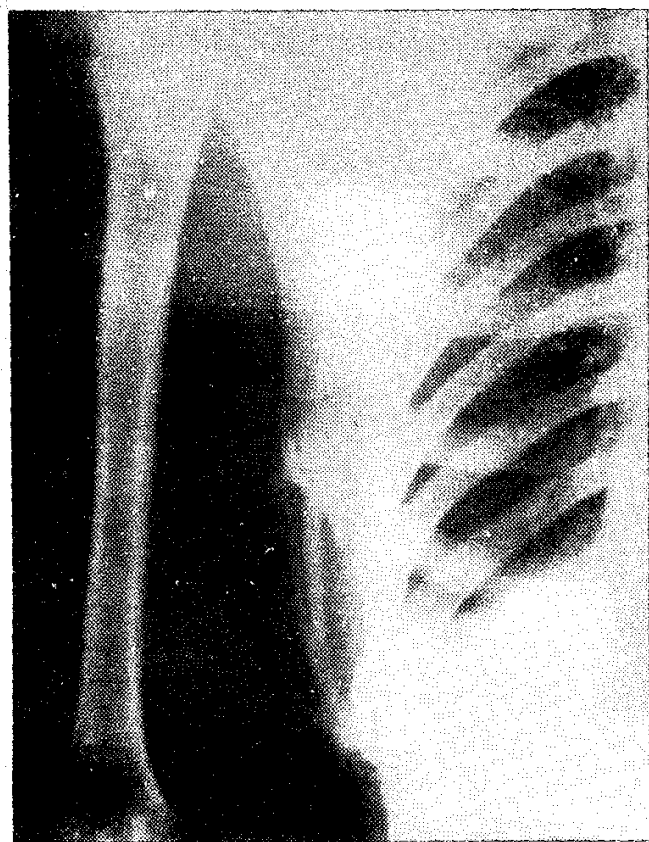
Radiograph showing ectopic ossification in the subscapular region.
